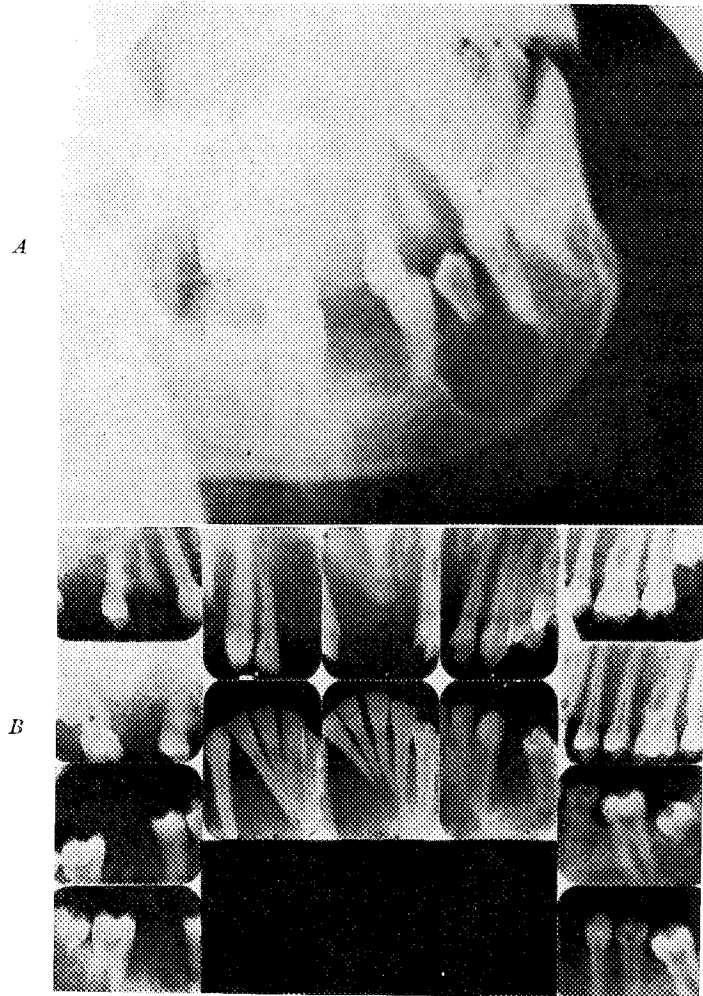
Sept. 12, 1955. A, Roentgenogram of right mandible. B, Periapical roentgenograms showing separation of teeth.
